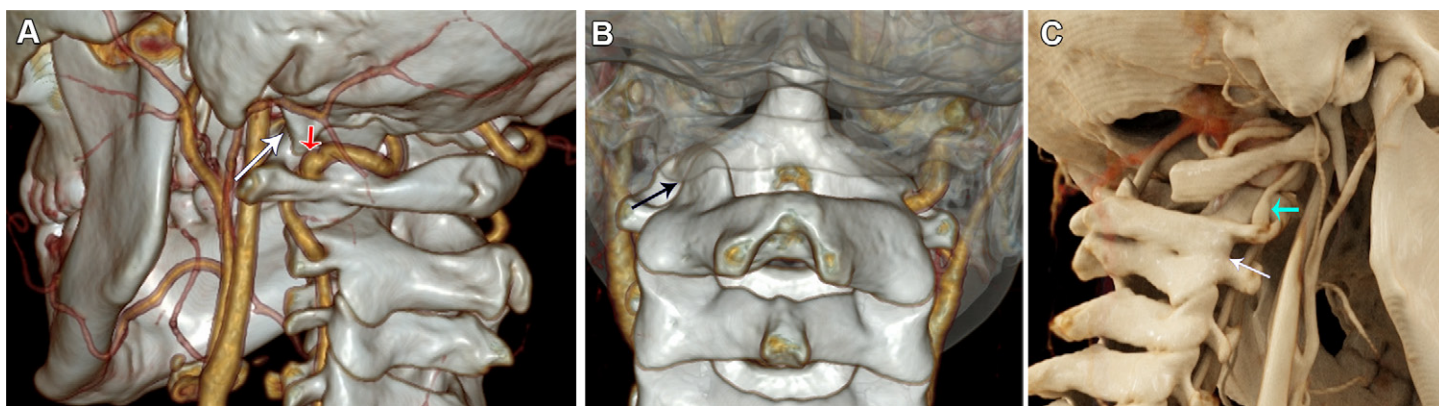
Anatomic variants believed to predispose to VAD in three children. (A) Left posterior oblique volume-rendered CT angiogram in a 16-year-old boy shows an anomalous occipital protuberance (white arrow) near a small left vertebral artery pseudoaneurysm (red arrow). This dissection atypically involves the distal horizontal V3 segment rather than the much more commonly involved proximal V3 segment. (B) Posterior volume-rendered CT angiogram in a 12-year-old girl shows an accessory left C1-C2 facet joint (arrow) adjacent to the C2 transverse foramen. The left vertebral artery was occluded at the V2 level. This anomaly may alter atlantoaxial mechanics and predispose to vertebral arteriopathy. (C) Right posterior oblique volume-rendered CT angiogram in a 10-year-old girl with Klippel-Feil syndrome and VAD shows C2-C3 interbody fusion, with asymmetric fusion of the posterior elements (white arrow). An incomplete posterior arch of C1 is also present. A right vertebral artery pseudoaneurysm (green arrow) is observed, and vertebral artery occlusion (not shown) was seen at follow-up imaging performed on day 57 after presentation.
